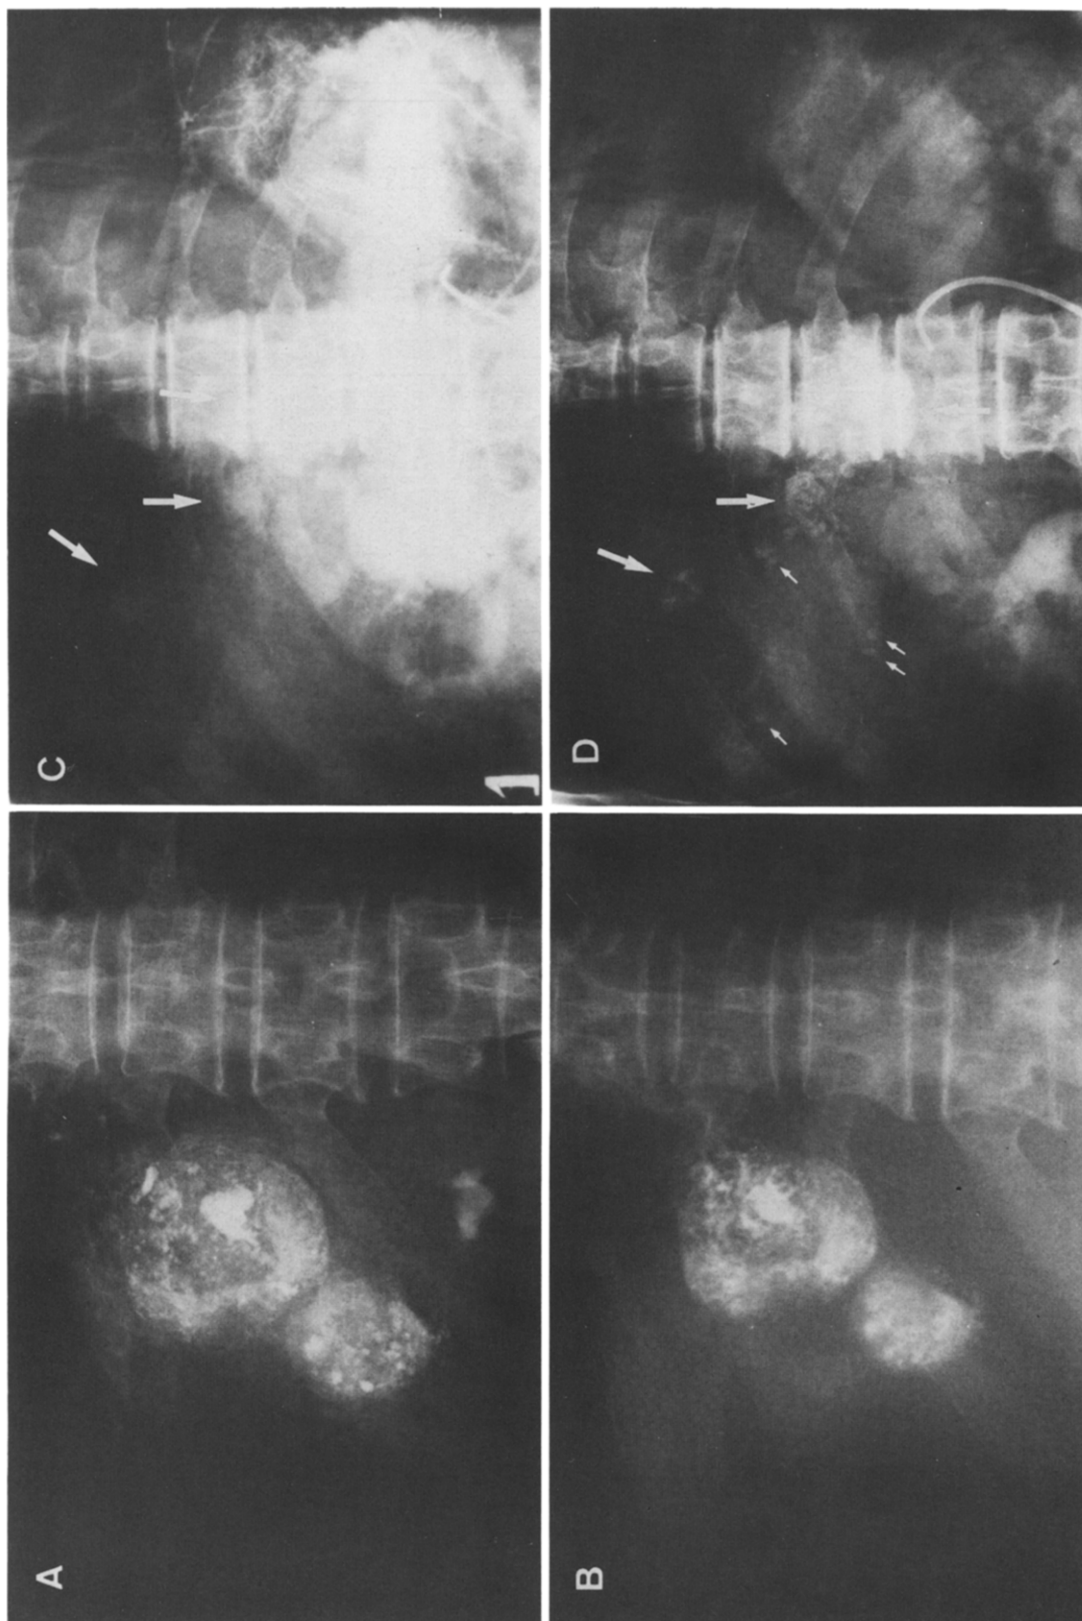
Abdominal plain X-ray film. (A) Immediately after administration of SMANCS-ethiodol (case 17); (B) 1 month after administration (case 17); (C) capillary phase of common hepatic arteriogram (case 26); (D) immediately after administration of SMANCS-ethiodol a small sized cancer nest of 4 mm in diameter is also clearly detected (see arrows) (case 26).
